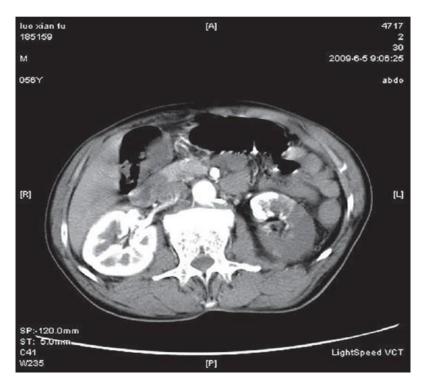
Axial enhanced abdominopelvic CT scan of SCD patient showing renal infarction
